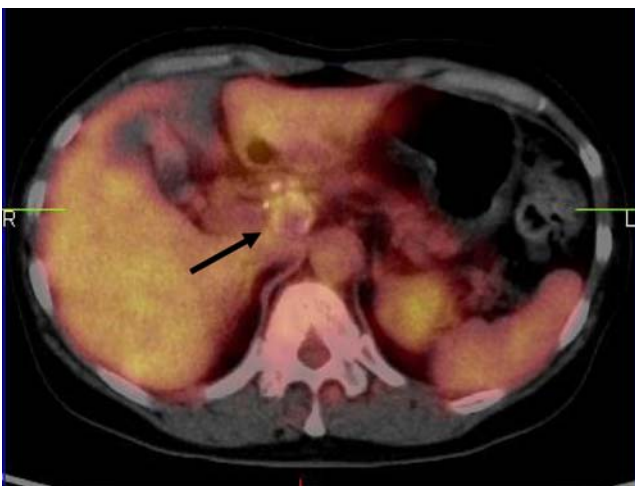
FDG-PET imaging co-registered with CT shows slightly increased uptake of FDG along the periphery of the lesion (arrow).
